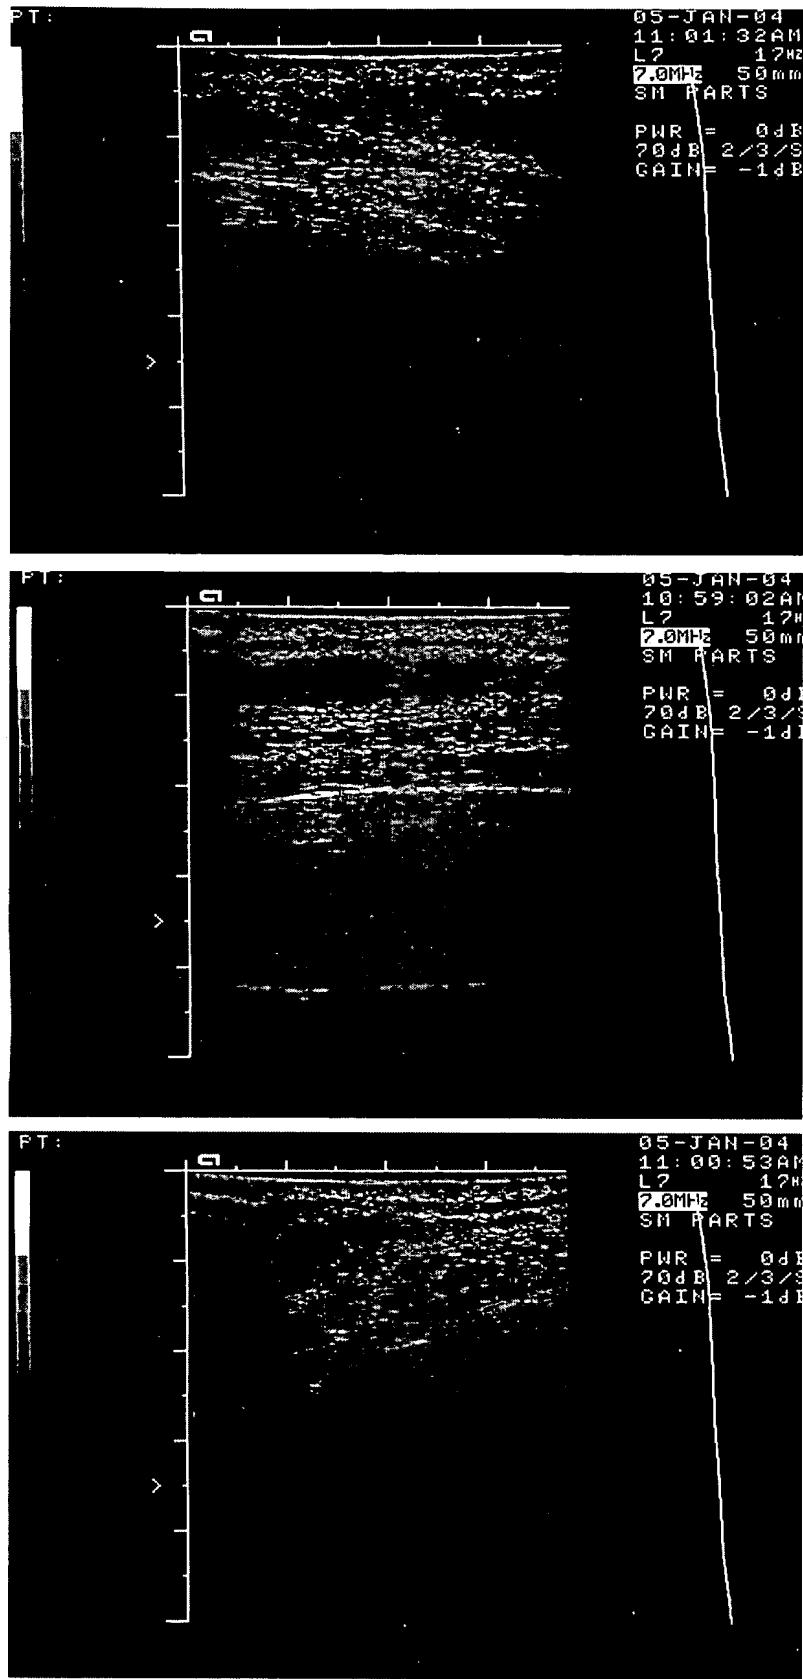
Modification of the ultrasonic scanning pattern on the site of insertion of B-16 cell culture.
